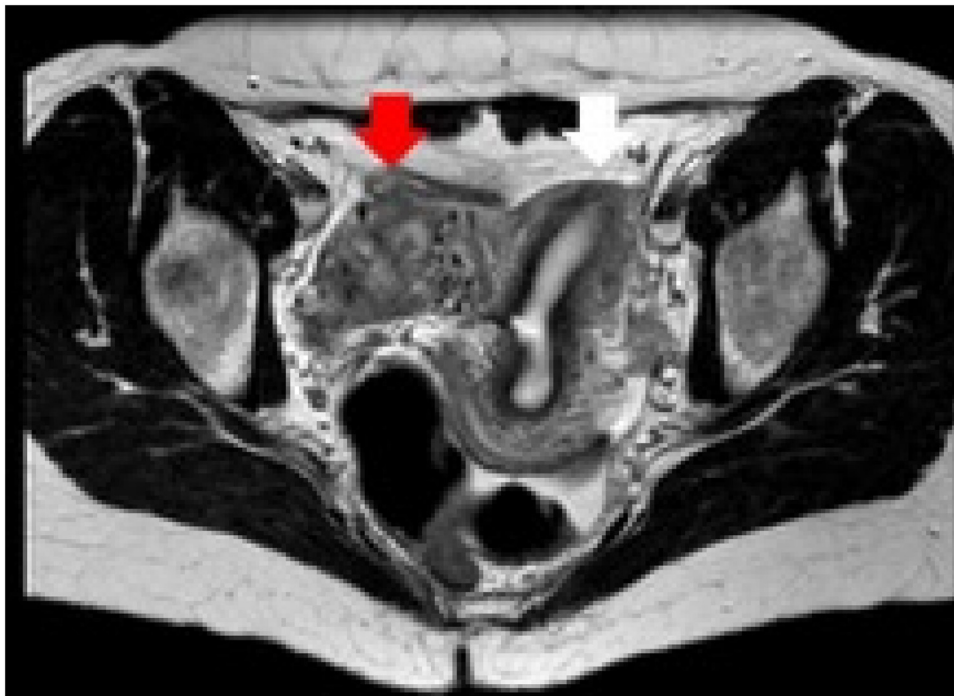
Magnetic resonance image of the pelvis: axial view of the left hemi-uterus (white arrow) and the right rudimentary horn (red arrow) with involutive trophoblastic residues. (For interpretation of the references to colour in this figure legend, the reader is referred to the web version of this article).
